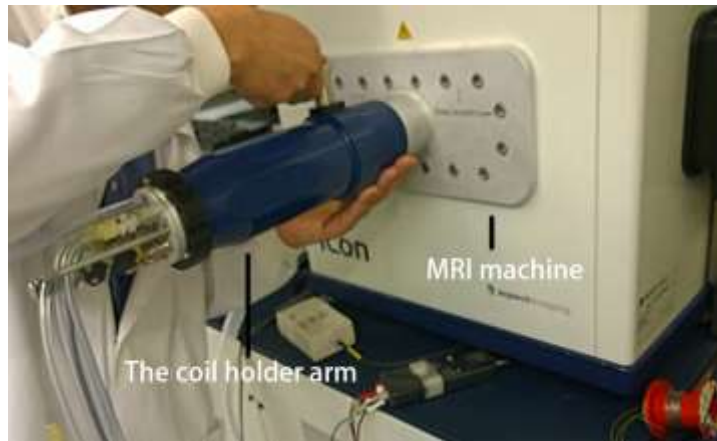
The Bruker ICON™ MRI machine at the Centre for Advanced Biomedical Imaging of UCL
